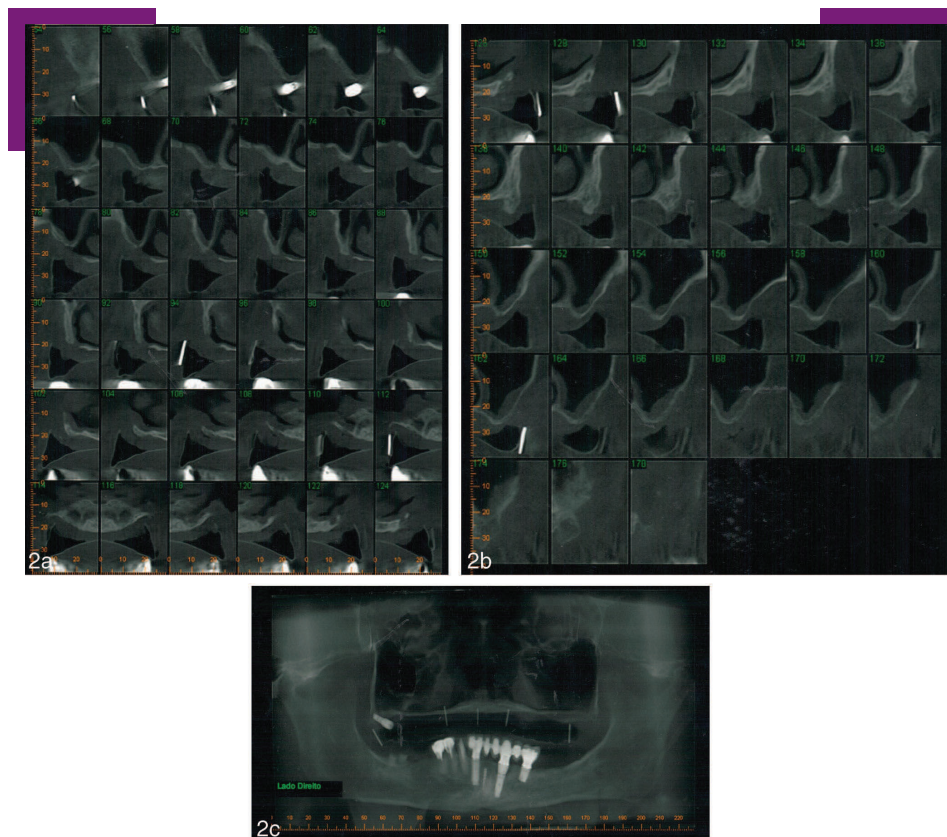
Initial cone beam computed tomography. (a) and (b) refers to transversal reconstruction and (c) panoramic reconstruction. Observe the severe maxillary atrophy, bilateral pneumatization, and the absence of opacification of the maxillary sinuses.
